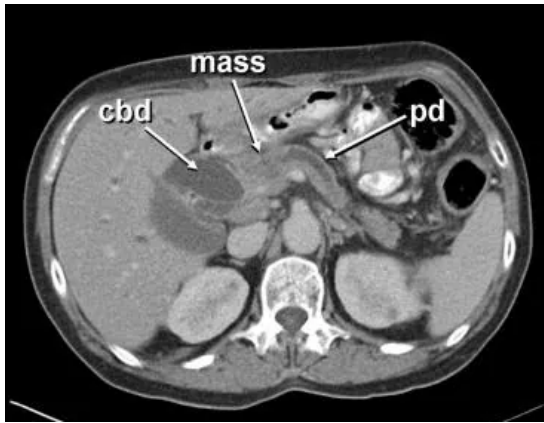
Computed tomography of the abdomen revealed a 3 cm × 4 cm mass over the head of pancreas which could not be differentiated from the adjoining duodenal wall.
